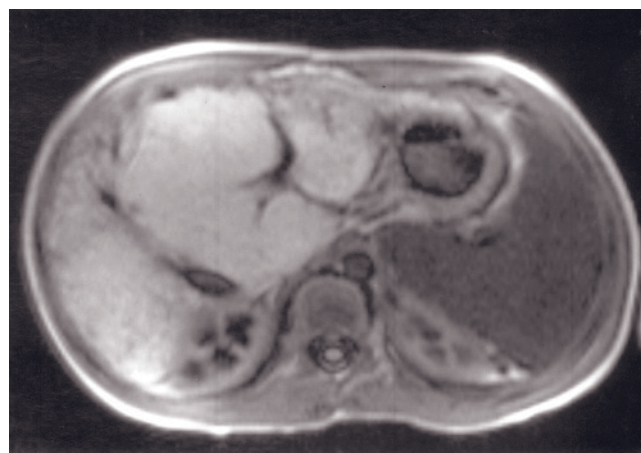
Chronic Budd-Chiari syndrome. SGE (a), proton-density fat-suppressed spin-echo (b), T2-weighted fat-suppressed ETSE (c, d), and immediate postgadolinium SGE (e) images. On T1-weighted images (a), multiple well-defined high-signal-intensity mass lesions representing regenerative nodules are identified, the largest measuring 3.5 cm in diameter (arrow, a). The proton-density image at the expected level of the hepatic veins (b) demonstrates absence of hepatic veins, with intrahepatic curvilinear venous collaterals in their stead (arrow, b). Enlargement of the caudate lobe is shown (small arrows, b). The T2-weighted image (c) taken from a slightly higher tomographic section demonstrates curvilinear intrahepatic collaterals (arrow, c) with absence of hepatic veins. The immediate postgadolinium image (e) acquired at the same tomographic level as the precontrast images (a, d) shows enhancement of the regenerative nodules, with multiple enhancing nodules apparent that were not visualized on precontrast images. Slight heterogeneity of hepatic enhancement is present. The enhancement pattern is distinctly different from that of acute Budd-Chiari syndrome.
